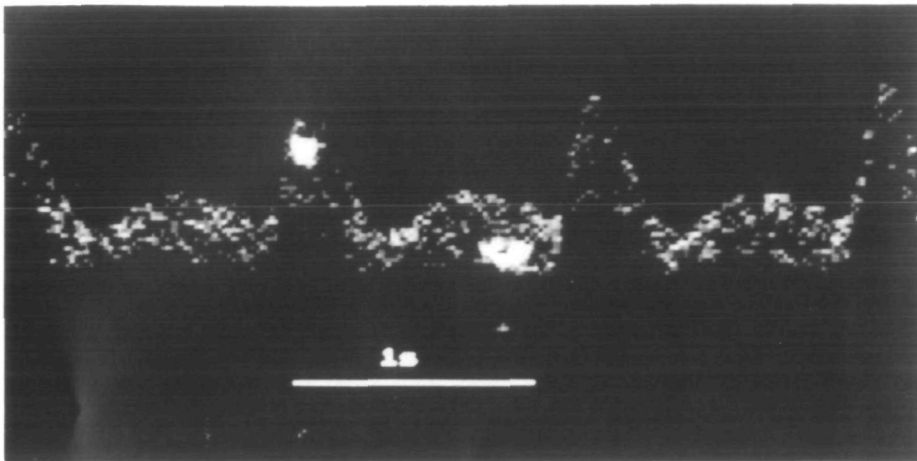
Doppler recording from the in vitro model. The flow pattern approximated that of the human middle cerebral artery. Two high-intensity embolic signals due to 250- μ m glass microspheres are seen. The effect of velocity on duration of high-intensity signal can be seen, with the lower velocity signal having a longer duration. Intensity is coded on a gray scale, with white indicating high intensity.
